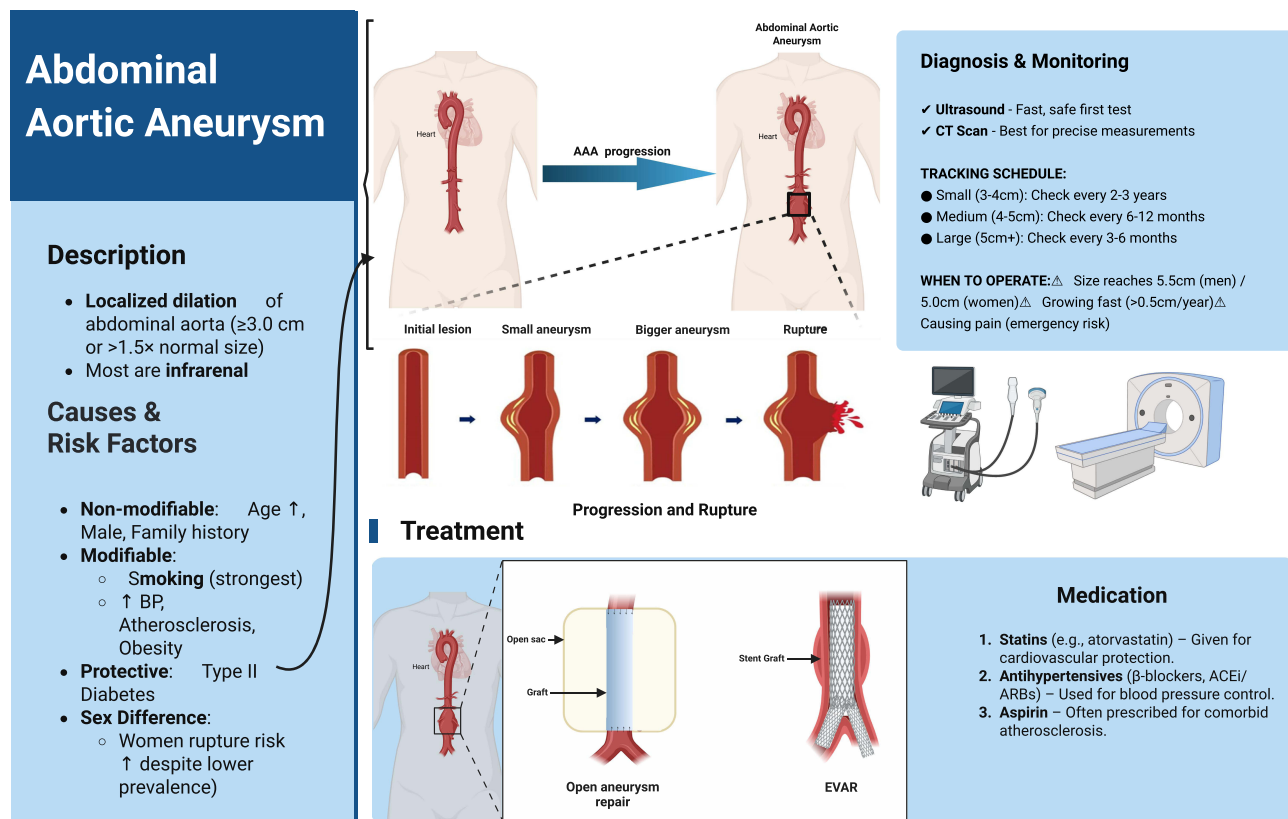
Overview of abdominal aortic aneurysm (AAA). This figure summarizes the definition, risk factors, progression, diagnosis, and treatment of AAA. It shows how aneurysms develop and may rupture, highlights key risk factors (eg, age, male sex, smoking), and outlines diagnostic tools (ultrasound, CT) and monitoring intervals. Treatment includes surgical options (open repair, EVAR) and medications like statins, antihypertensives, and aspirin for cardiovascular protection. (↑ indicates increase). This figure is generated using <https://BioRender.com>.
